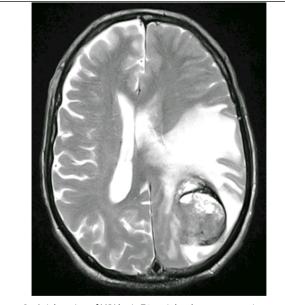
Axial section of MRI brain T1-weighted post-contrast image of the same patient, showing heterogenous hyperintense signals and subtle contrast enhancement.
